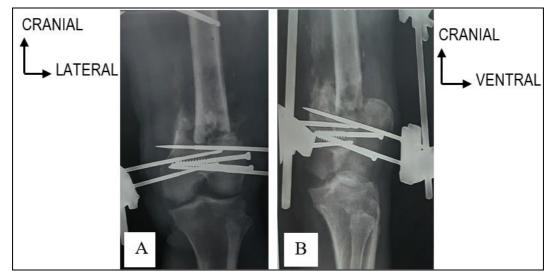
Osteosynthesis by external fixator. A. Front X-ray; B. Profile X-ray
